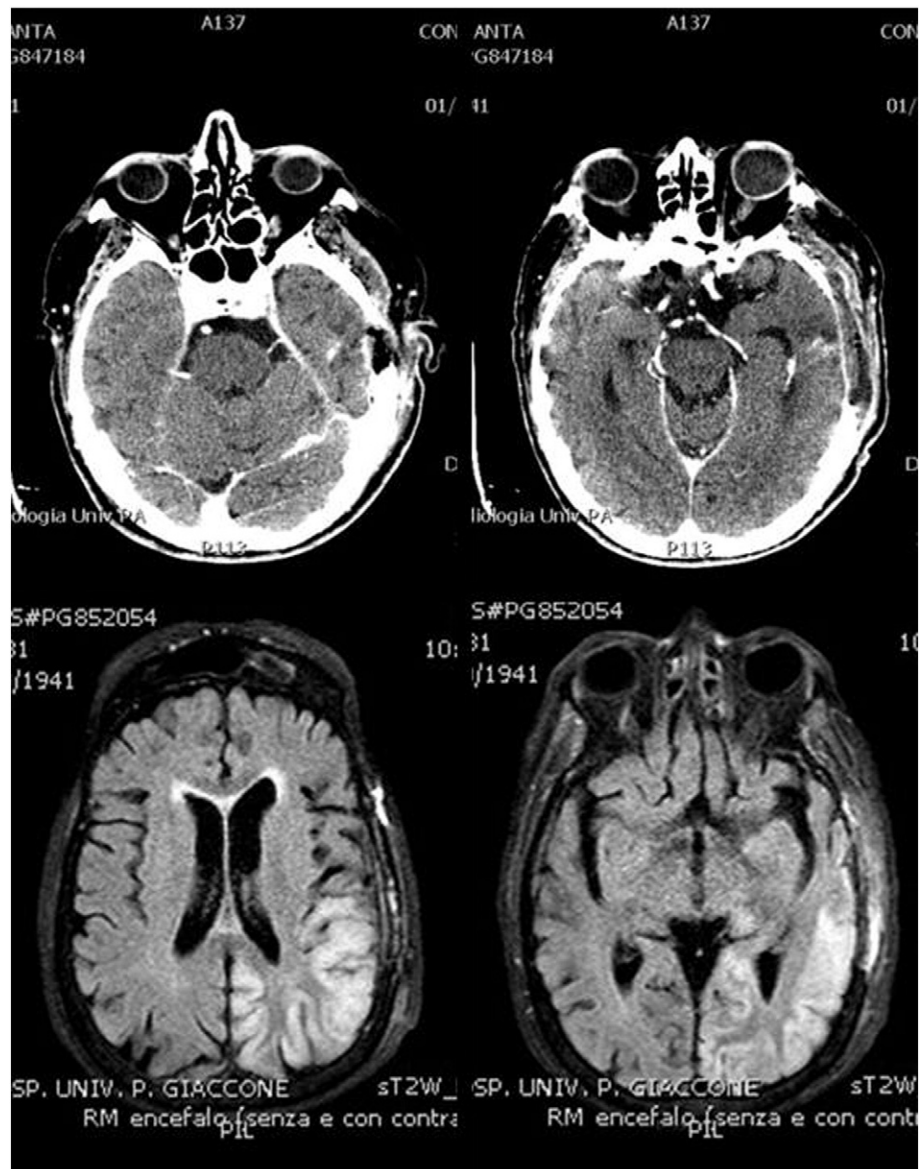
Brain CT and MRI images: a parenchymal alteration in the left temporal lobe is depicted and intense brain swelling is documented in the T2-weighted MRI sequences on the bottom.
